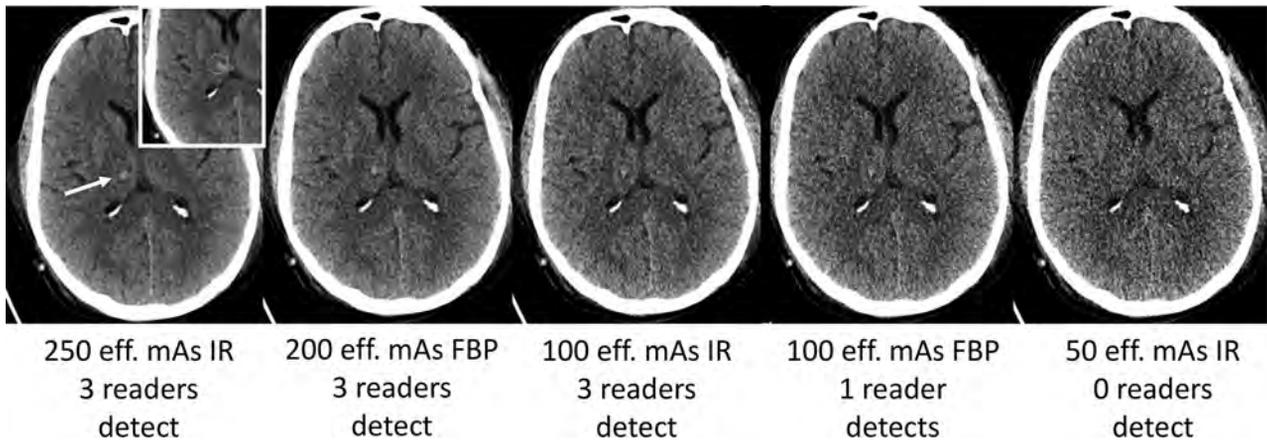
Small right thalamic hemorrhage (*white arrow*) shown on routine-dose CT image (250-eff. mAs IR) along with lower-dose configurations. The small left inset shows reference neuroradiologist markings of the target lesion (*green circle*). This CT examination was performed after trauma, with hemorrhage confirmed surgically, and the final diagnosis was recorded as right thalamic hemorrhage consistent with shear injury.
